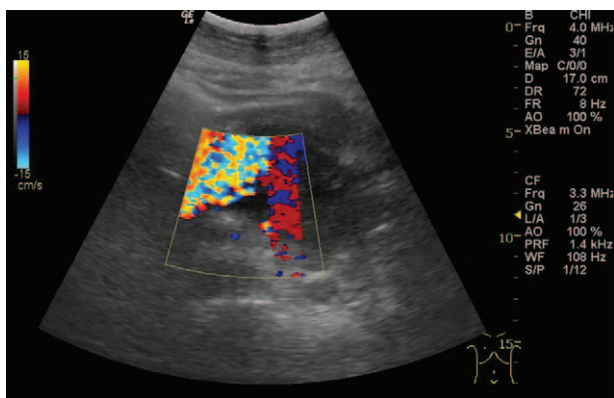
The color Doppler imaging is similar to the blood flow signals (areas outlined in yellow) when injecting fluid to reveal the presence of nasojejunum tube.
